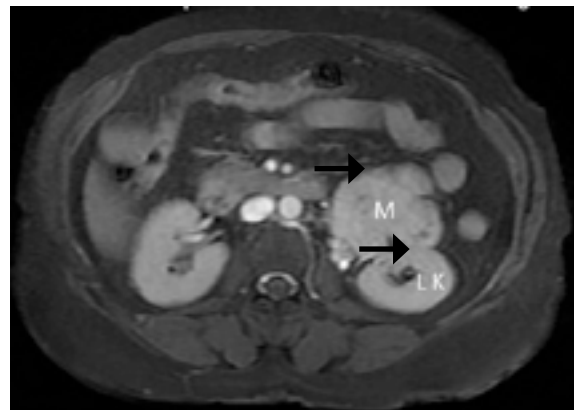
MRI showing a well defined lobulated heterogenous lesion in left anterior renal space (M-mass, LK-left kidney)
